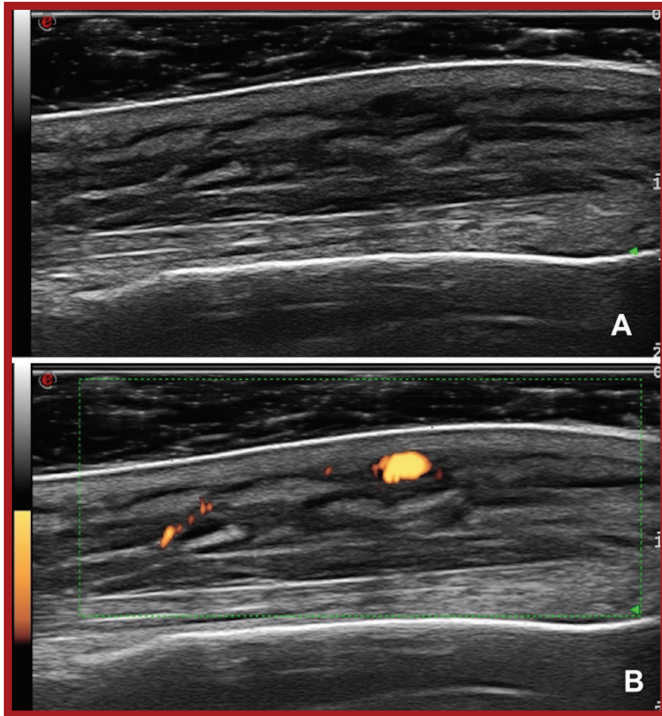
Dorsal longitudinal ultrasound view of hand. Remarkable decrease in echogenicity and increase in thickness of subcutaneous tissue (A) with grade 1 Doppler signal activity (B) are shown.
